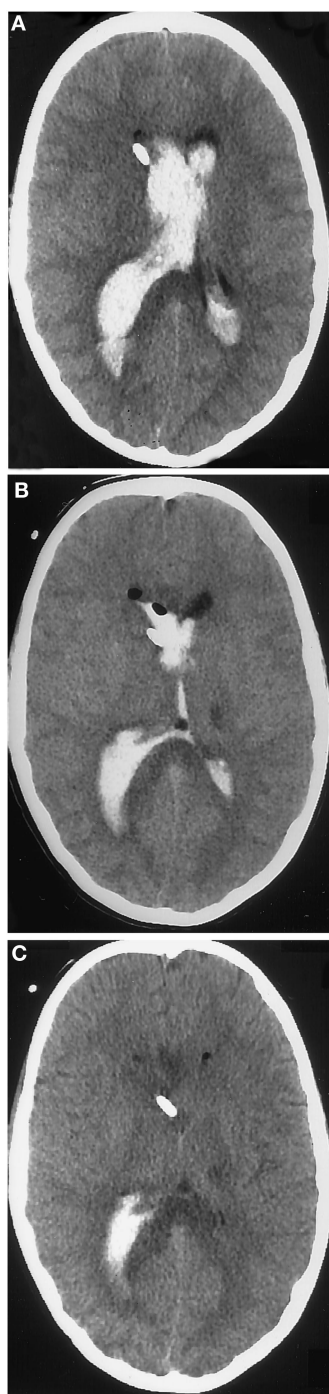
A and B, unenhanced axial CT scans of the head at two different levels obtained at admission to hospital, showing blood filling the lateral, third, and fourth ventricles.
